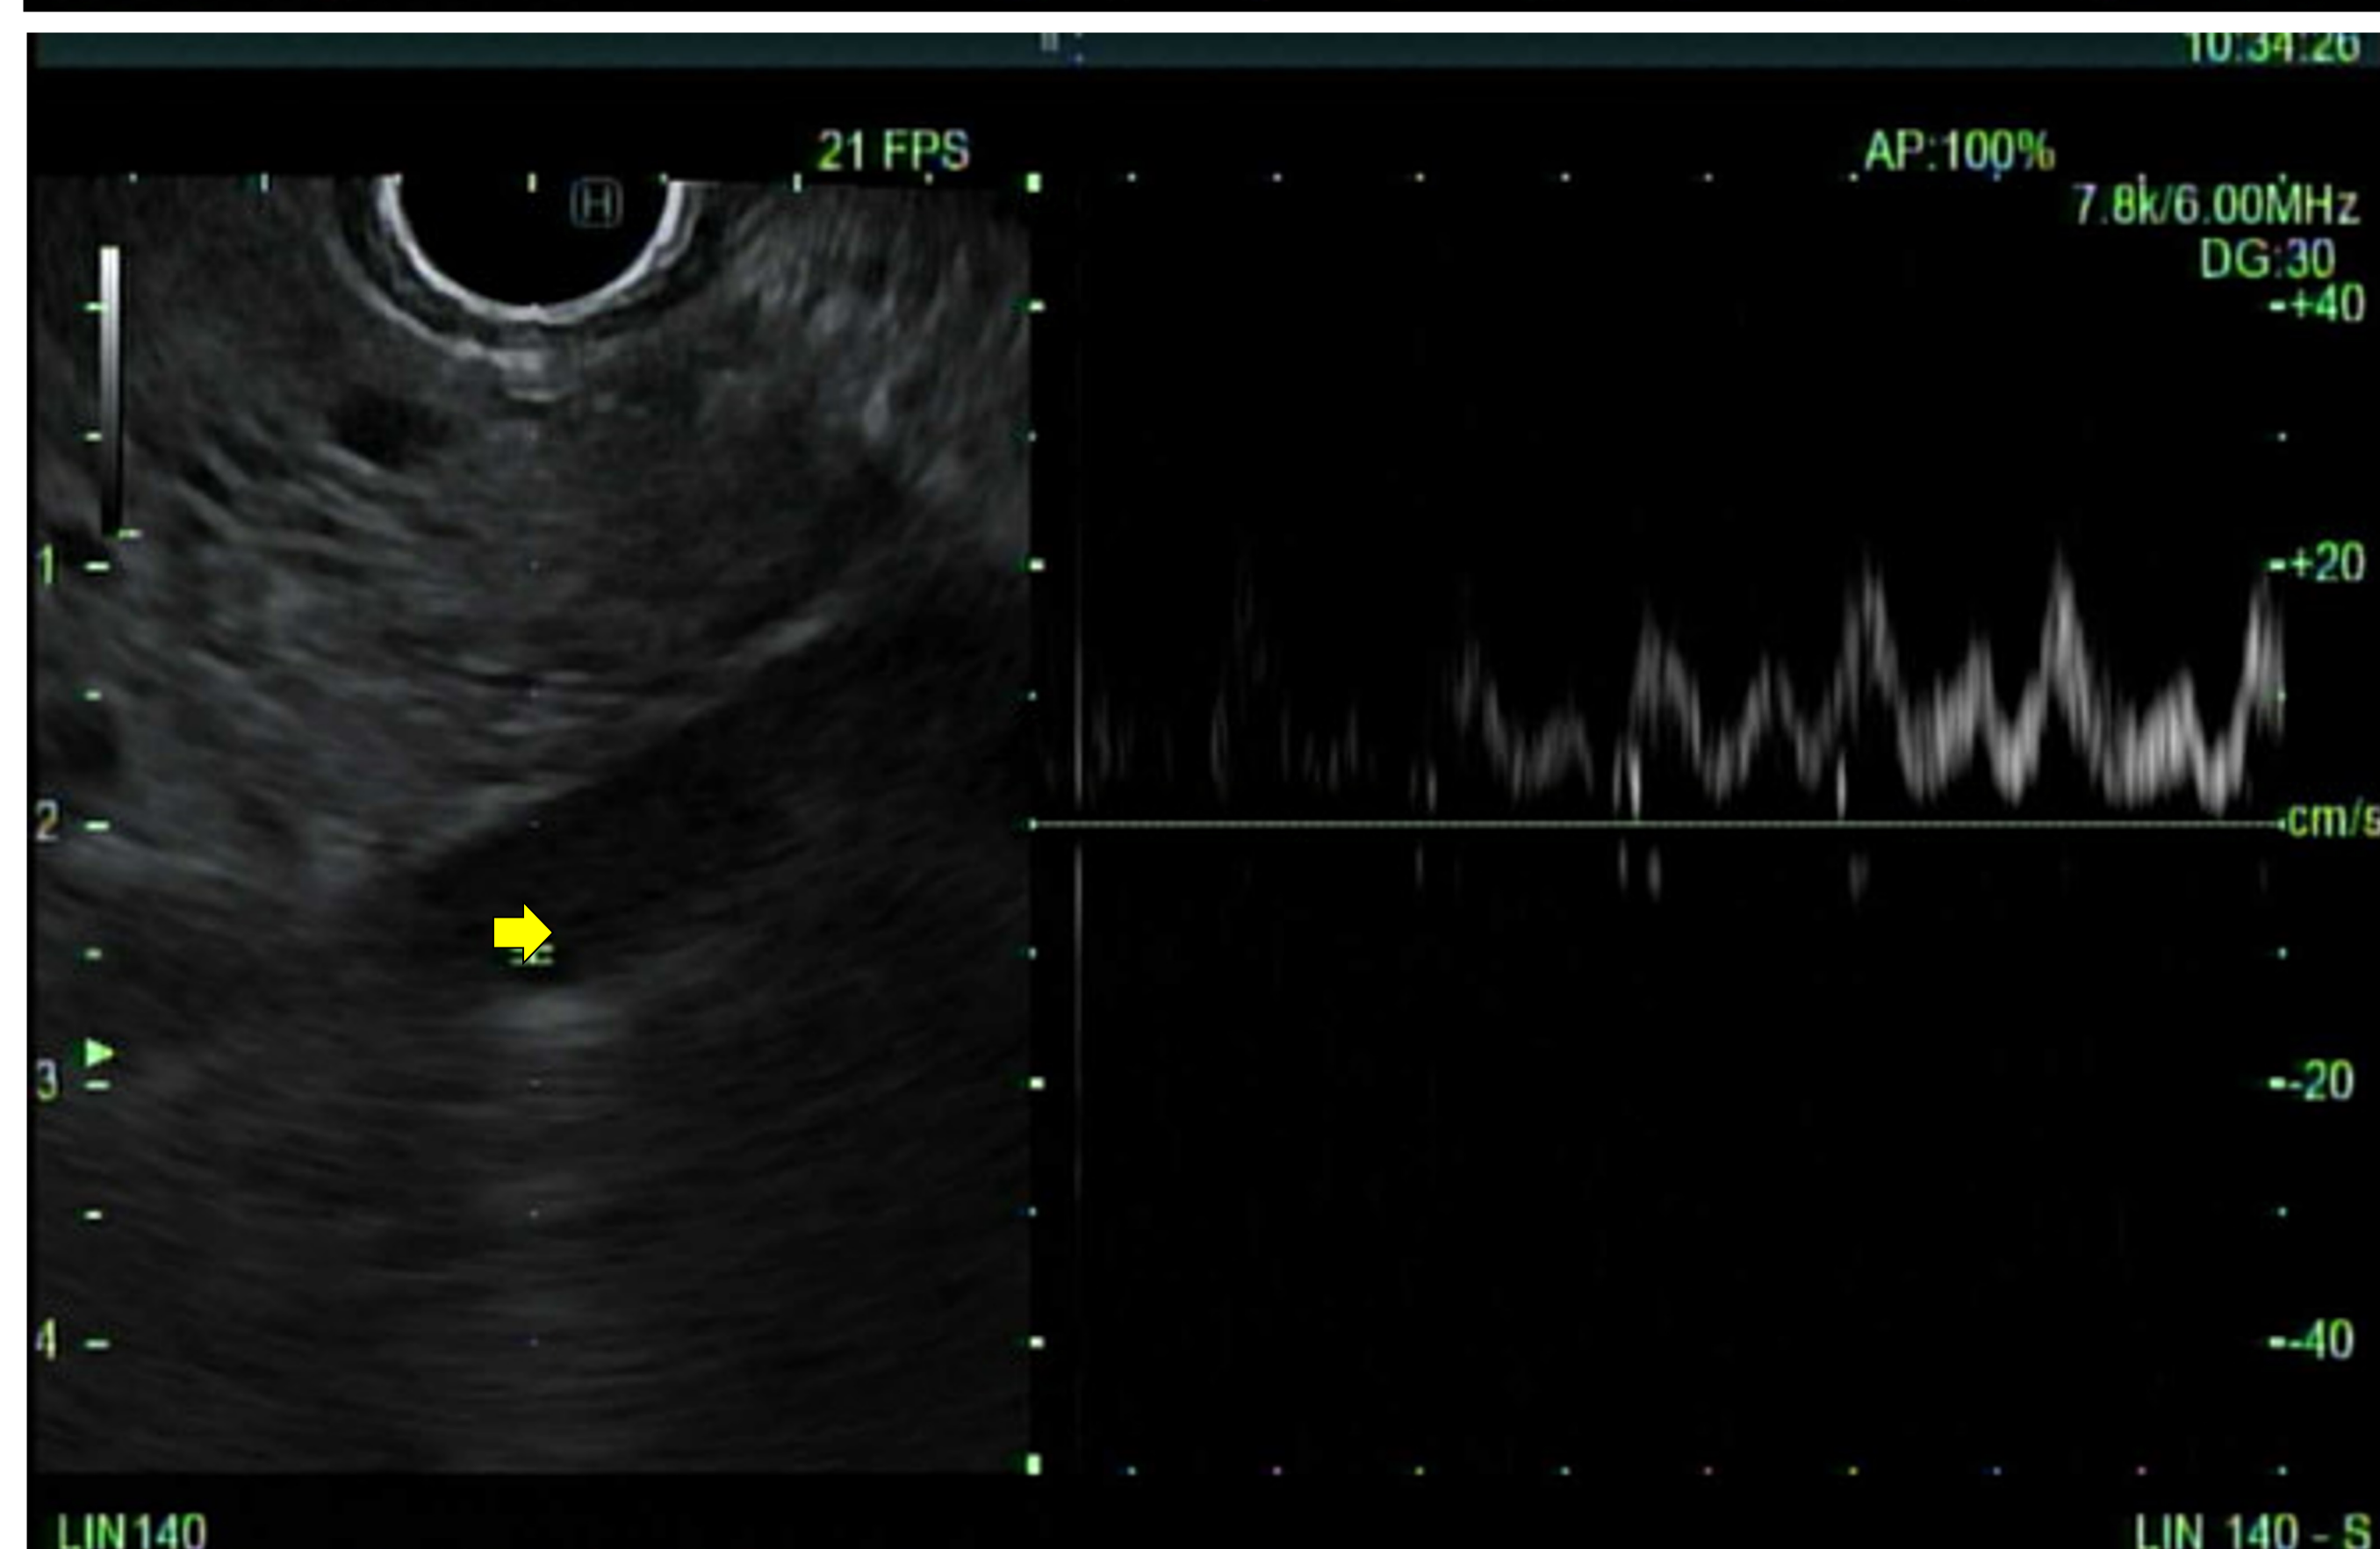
Doppler with waveform of hepatic vein.
